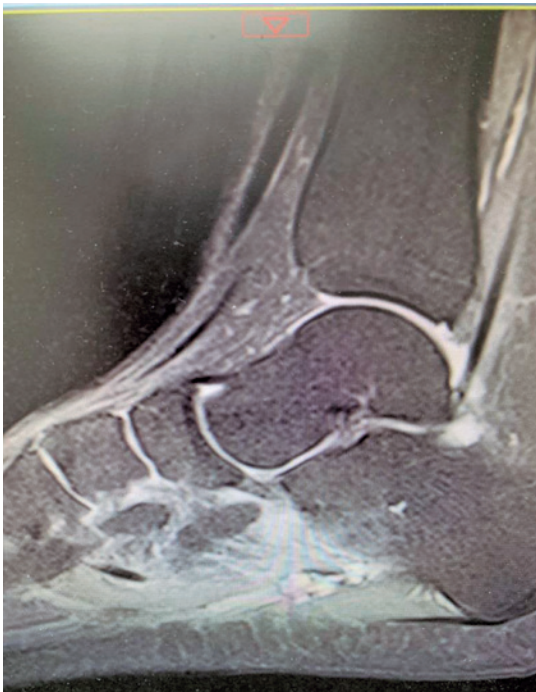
T2-weighted sagittal MRI scan performed in 2019 showing recurrence of the plantar lesion in a postoperative fibrosis area.
